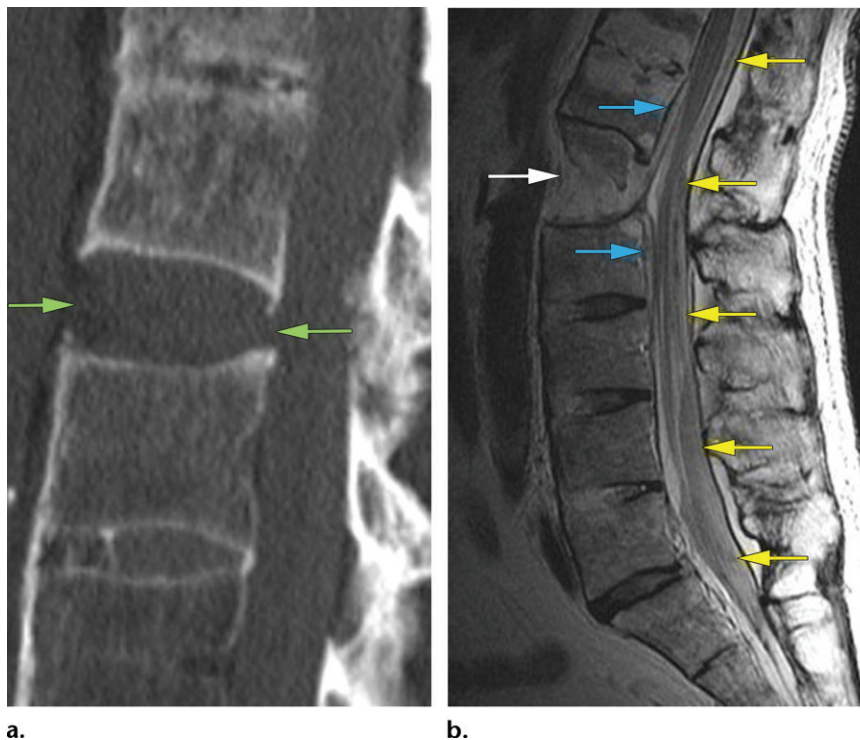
Hyperextension injury in a 50-year-old man with AS who slipped on ice and landed on his back. (a) Sagittal CT image shows distraction of the L1-2 disk space, with disruption of anterior and posterior fused ossified ligaments (arrows), a finding consistent with hyperextension injury. (b) Sagittal T2-weighted MR image shows the disruption of the ALL, disk, and posterior longitudinal ligament, with mixed intradiscal fluid and blood (white arrow), epidural hematoma (blue arrows), and extensive subdural and subarachnoid hematoma (yellow arrows).
